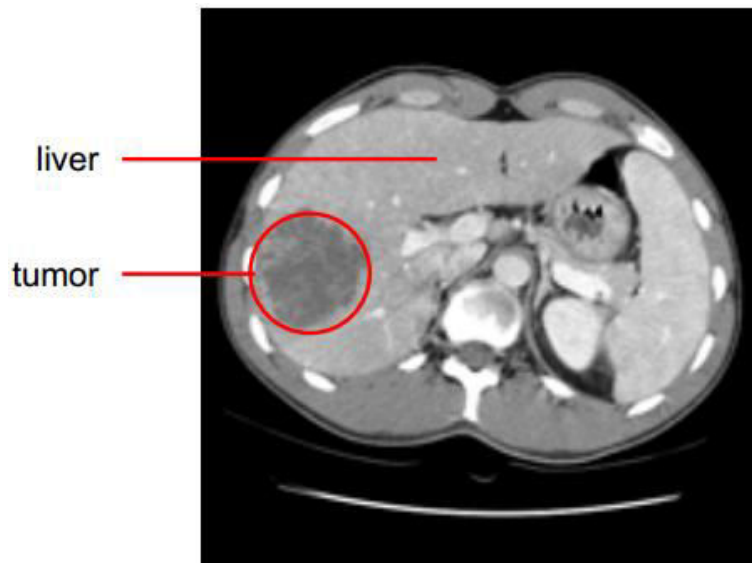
Axial view of the liver CT slice containing a tumor as a darker region indicated by red circle
